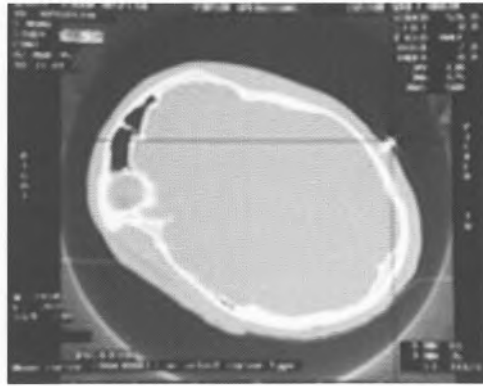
Tacks as fiducials. Stereotactic CT scan showing a tack serving as the fiducial, with the head of the tack serving as the centroid.
